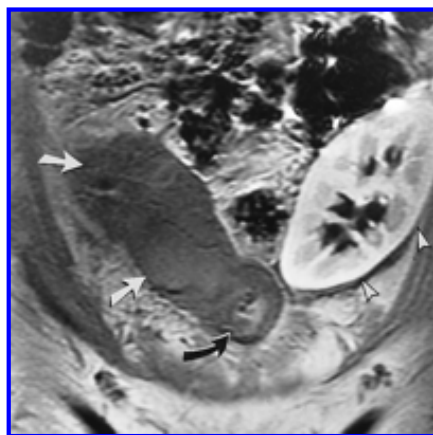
Coronal fast multiplanar spoiled GRE MR image (150/4.2, 60° flip angle) obtained 1 minute after the administration of gadolinium-based contrast material in a patient with pancreatic allograft infarction that was proved at surgical explantation. There is no enhancement in the enlarged pancreatic allograft (white arrows) or in the duodenal cuff (black arrow). The measured MPPE was 1%. A normal enhancing renal transplant (arrowheads) is noted.
